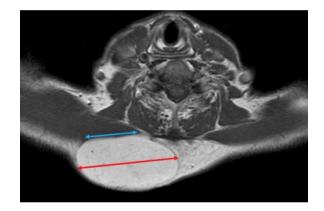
The tumor touches the underlying structures minimally. Axial T1-weighted MRI shows a lipoma in the right shoulder. The maximum diameter of the tumor (red two-headed arrow) is 82 mm long. The length where the tumor base touches the underlying structures (blue two-headed arrow) is 39 mm long. This case belongs to the "minimally touching" category because the ratio of the maximum tumor diameter to the tumor base length that touches the underlying structures is 0.47 and thus below the 0.5 threshold
